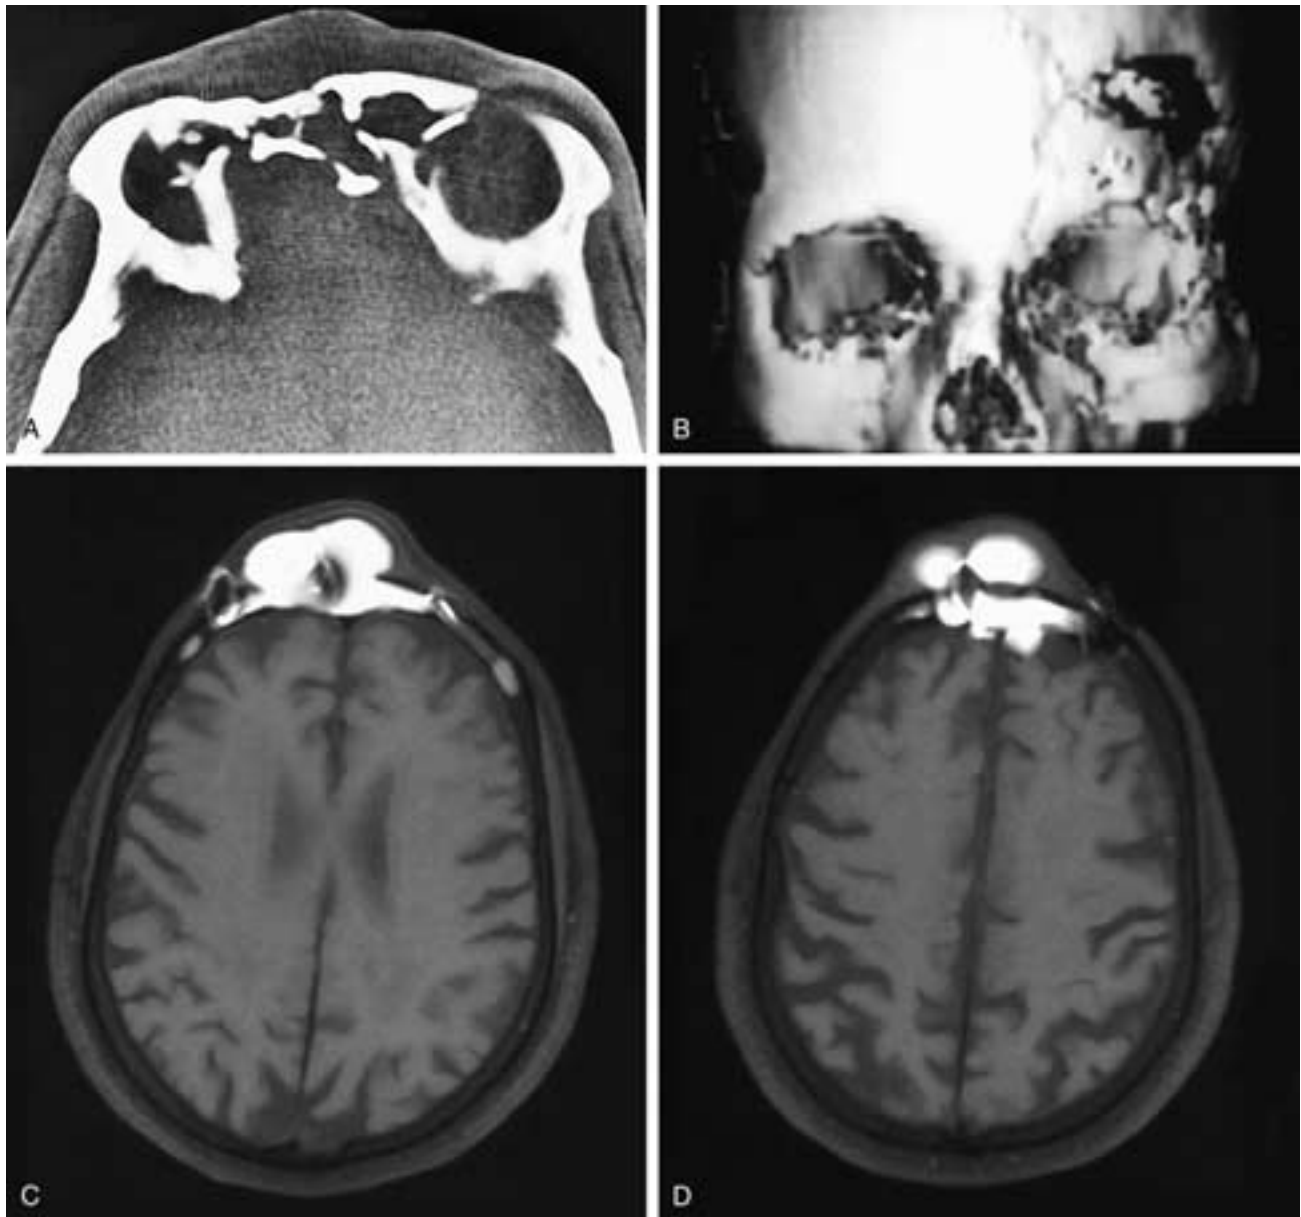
Axial CT scan (A) shows a comminuted midfacial fracture that involves the orbital roof bilaterally, as well as the anterior and posterior frontal sinus walls. Coronal 3D reconstructed image (B) on a different patient shows a markedly depressed left frontal bone fracture that involved the lateral margin of the left frontal sinus. As in Figure 7-42, frontal bone fractures often may involve the frontal sinuses. Axial T1-weighted, fat-suppressed MR images (C, D) on a patient who had prior frontal sinus trauma and an osteoplastic flap repair and then reinjured the frontal sinus. Hemorrhage has occurred within the flap fat, expanding it through the anterior and posterior fracture defects.
